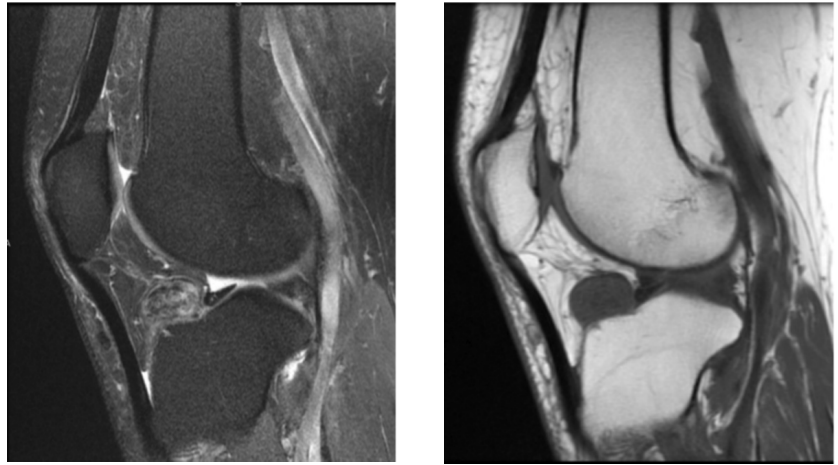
72-year-old man with giant-cell tumor of the tendon sheath. MR imaging shows findings typical of intra-articular GCTTS (PVNS). Left: Sagittal T1 weighted image shows low signal. Right: Proton density with fat saturation shows intermediate signal.
